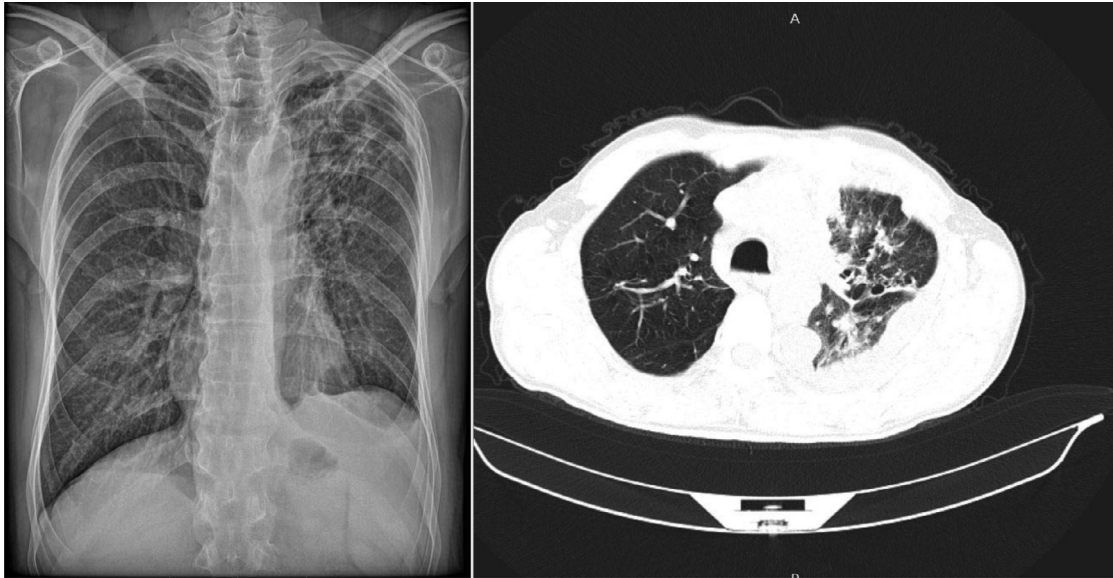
The results of the fourth chest radiography and the MSCT
